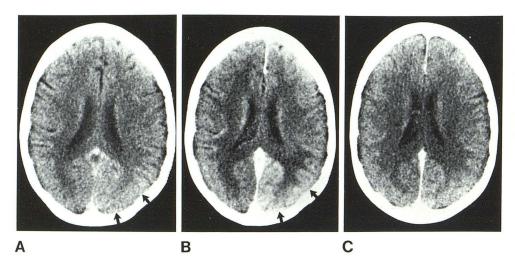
Case 1, postictal gyral enhancement. A, Unenhanced CT scan 1 hr after last seizure demonstrates equivocally increased attenuation in left parietooccipital cortex (arrows). B, Marked left parietooccipital gyral enhancement after intravenous contrast administration (arrows). Note lack of edema or mass effect surrounding abnormality. C, Contrast-enhanced scan 5 days later shows return to normal. There was a residual mild right homonymous hemianopsia.
